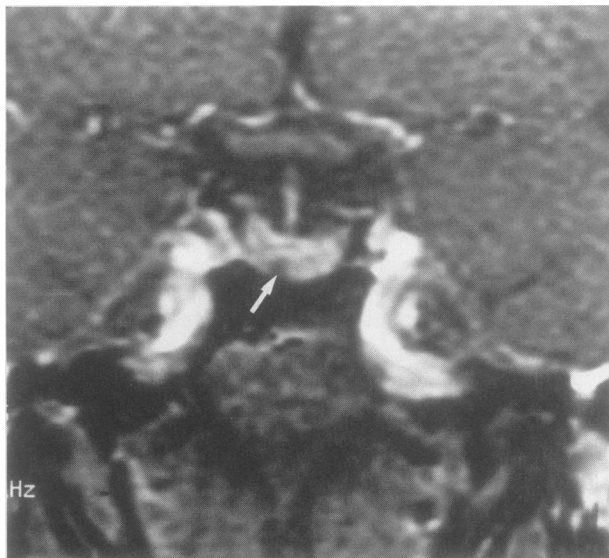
Coronal dynamic pituitary magnetic resonance scan: A T1-weighted coronal scan obtained during the infusion of gadolinium pentetate demonstrates a focal hypointense lesion (arrow) at the floor of the sellar just to the right of the midline.
